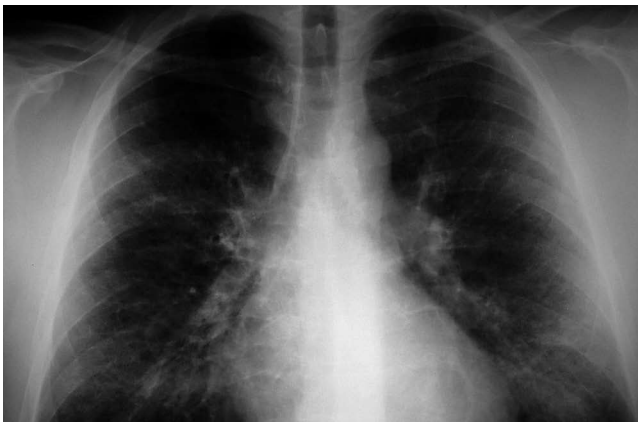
Chest X-ray (2003-09-09) showing moderate reticular enhancement with ring-like consolidation in both lungs (but predominantly the right), without cardiac or aortic abnormalities.
